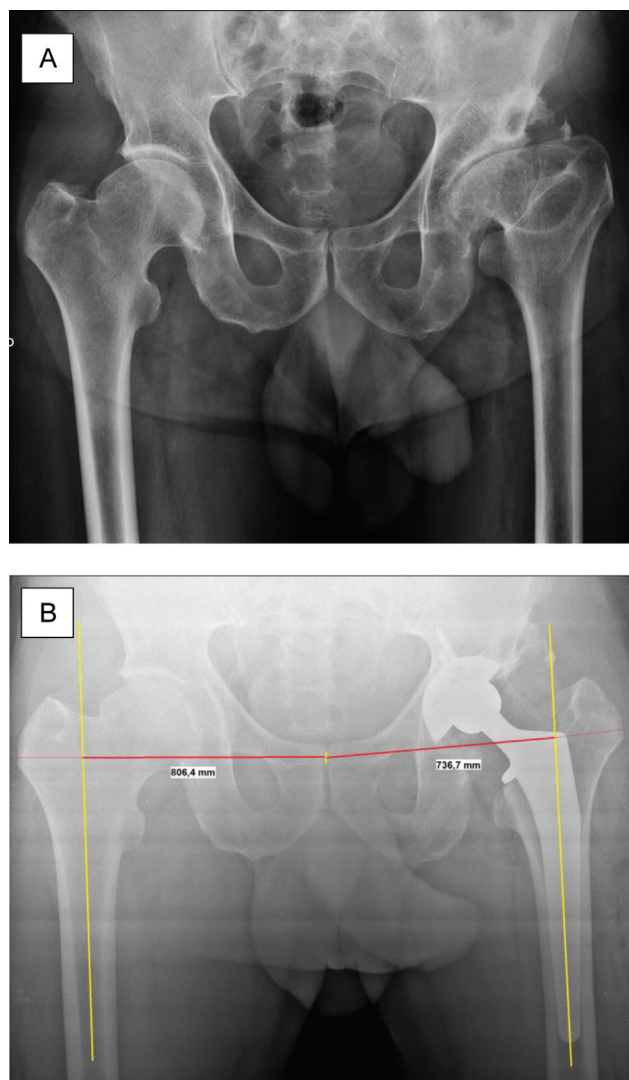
Femoral offset calculation in anteroposterior radiographs of the hip. (A) Preoperative period. (B) Immediate postoperative period, with differential lateral femoral offset of - 69.7 mm.
